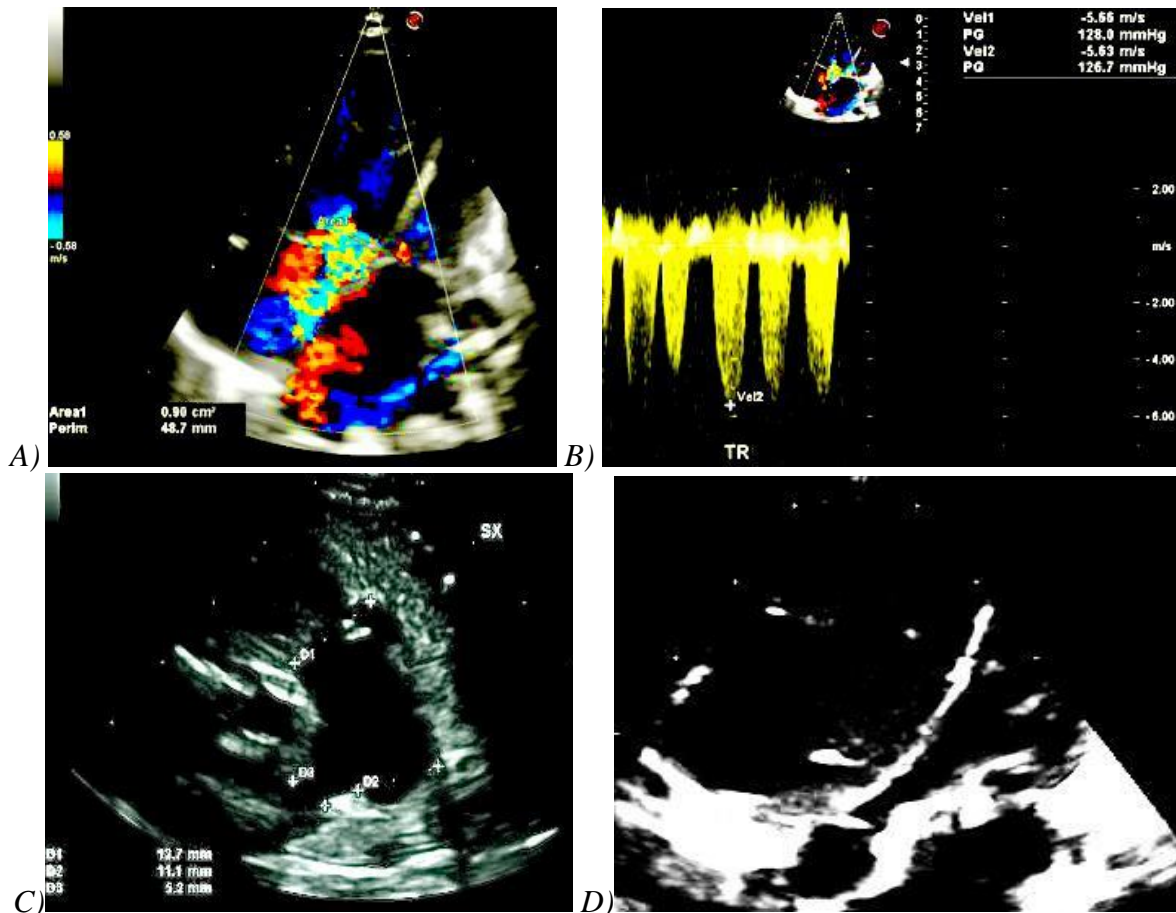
A) A highly turbulent tricuspid regurgitation jet was visualised in the apical 4CH view. B) On continuous wave doppler analysis a tricuspid regurgitation velocity of 5.63 m/sec was present with a peak gradient of 126.7 mmhg. C) There was notable dilation of main and branch pulmonary arteries. D) Dilated right ventricle with normal systolic function was identified.
